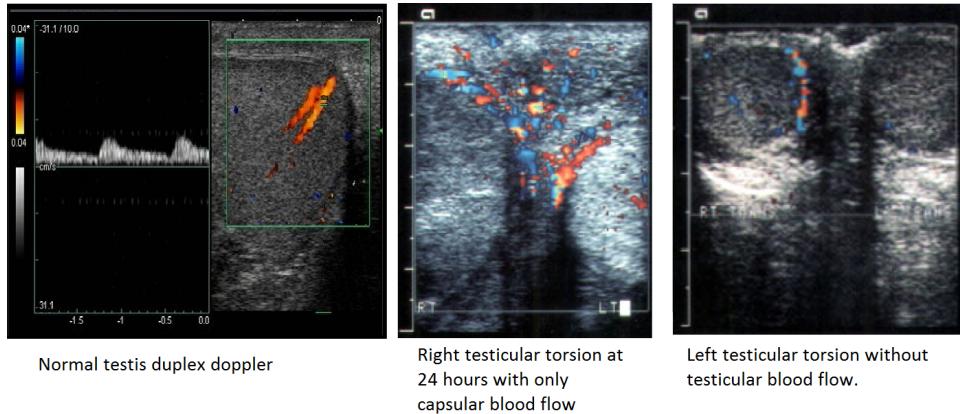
Testicular Torsion. Featured here is a series of doppler flow scrotal ultrasounds depicting normal testicular blood flow and torsion with capsular blood flow and torsion without testicular blood flow. Blood flow appear on color doppler as shades of blue and red depending on directionality from the probe.
